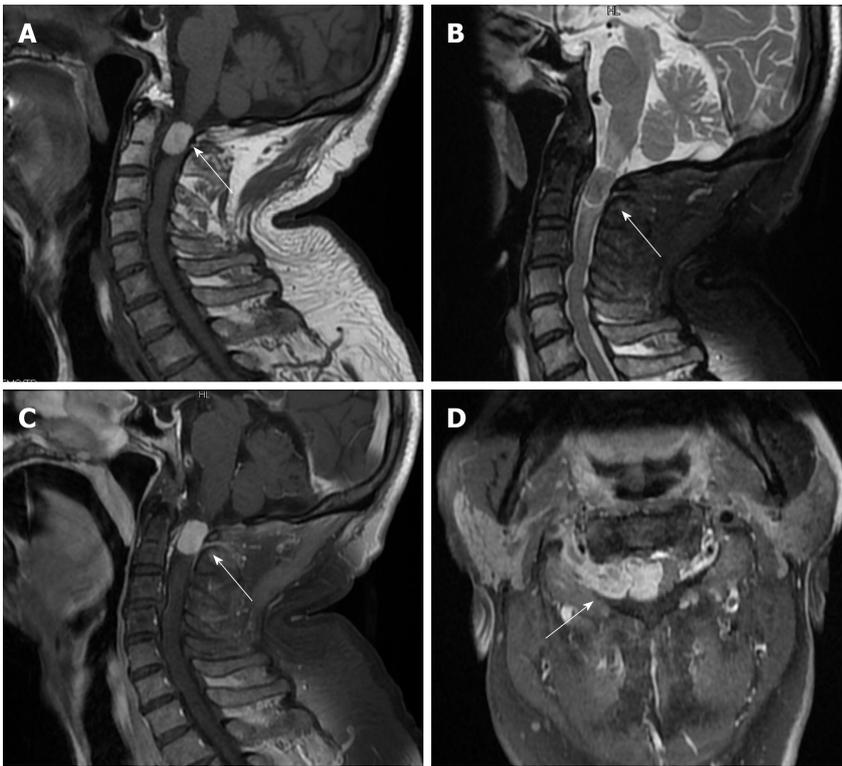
A: T1-weighted showed high-intensity; B: T2-weighted was equal-signal; C: Contrast Enhancement showed clear boundary, and the spinal cord is significantly compressed and displaced to the left side; D: White arrow the tumor grew out of spinal canal through intervertebral foramen.
